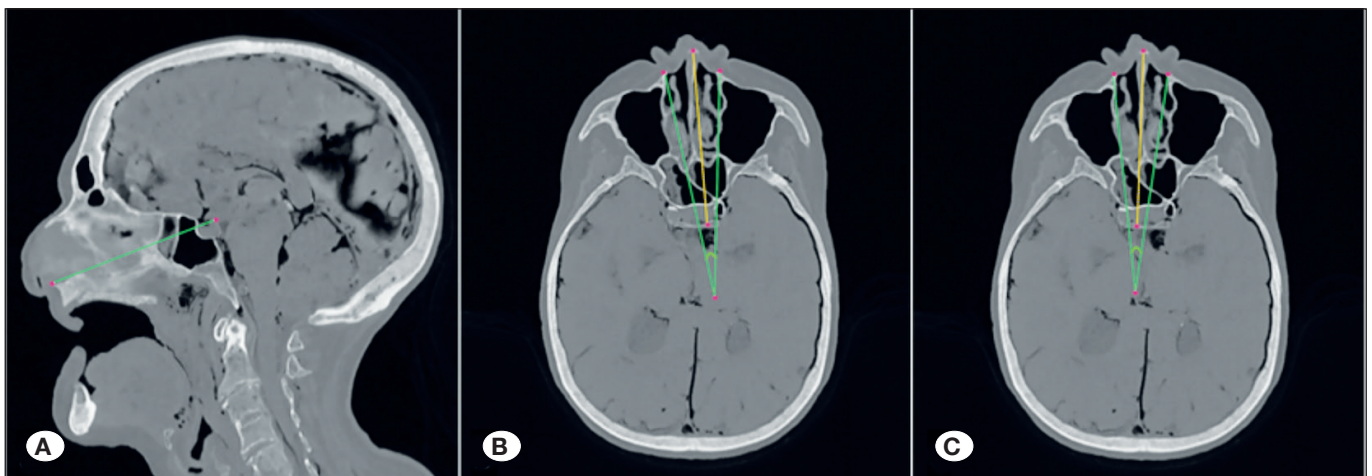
Preclinical measurements. Graphical representation of the EPHRA depth (A), left HRA (B), and right HRA (C) on axial CT scan with bone window visualization.
